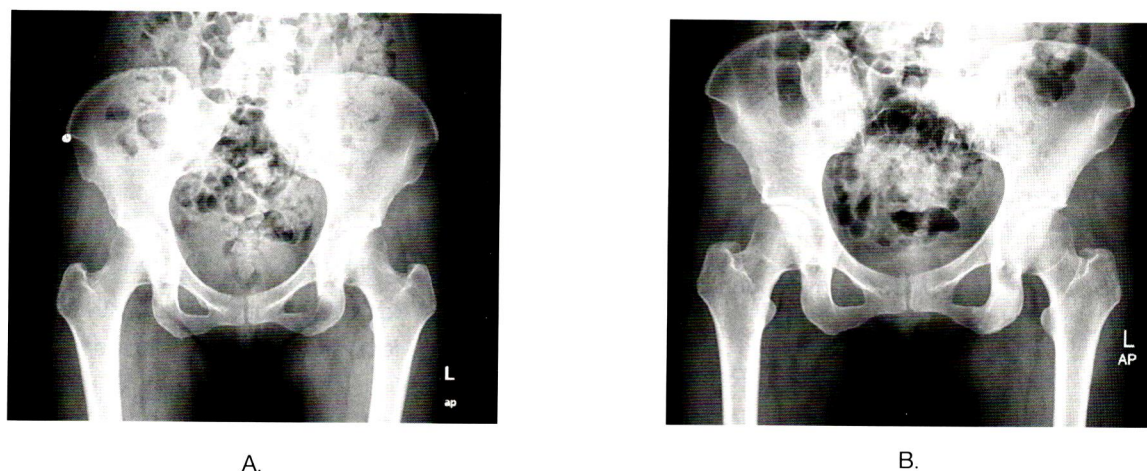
Follow up images were done at 18 months (A.) and 24 months. (B.) The first follow up image was unremarkable. However, sclerotic change of the left-sided sacrum and left inferior pubic ramus was clearly identified in Fig B. Bone metastasis was suggested. Multiple bone metastases in vertebrae and pelvis were confirmed in CT scan whole abdomen, which was obtained 2 months later.
